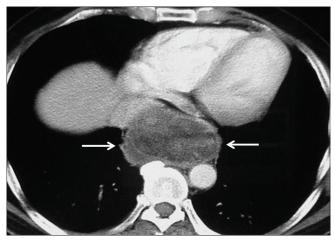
Esophageal pleomorphic liposarcoma. Contrastenhanced computed tomography axial images demonstrated a large well-circumscribed heterogeneous solid ovoid mass in the distal esophagus with some areas of fatty density (arrows)
